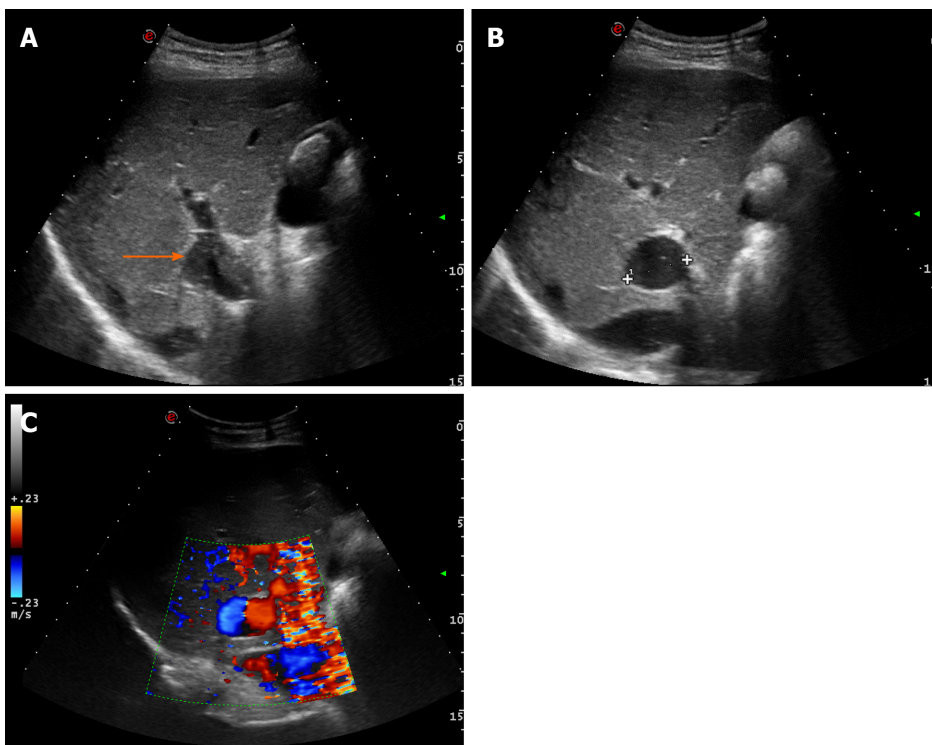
Abdominal ultrasonographic imaging of Case 3. A: Anechoic lesion of the right branch of the portal vein (arrow); B: The intrahepatic anechoic lesion was 27 mm at its maximal diameter; C: Colour Doppler showed the "Korean flag" pathological sign.
